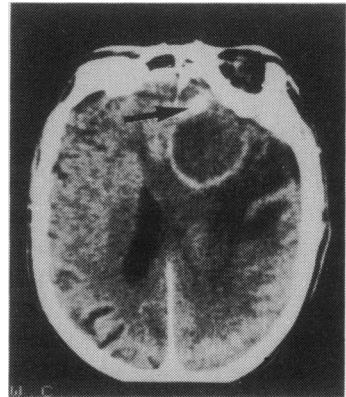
Contrast CT scan showing ring lesion with peripheral rim enhancement, surrounding oedema and midline shift. Hyperdense lesion (arrow) is presumably the larger fragment of glass.
